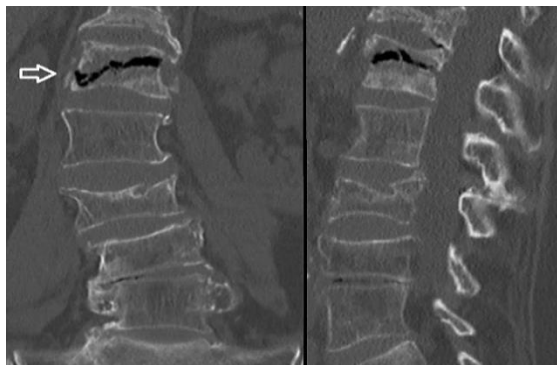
Intravertebral vacuum cleft sign (VCS), coronal and sagittal views of computed tomography (CT) scan
